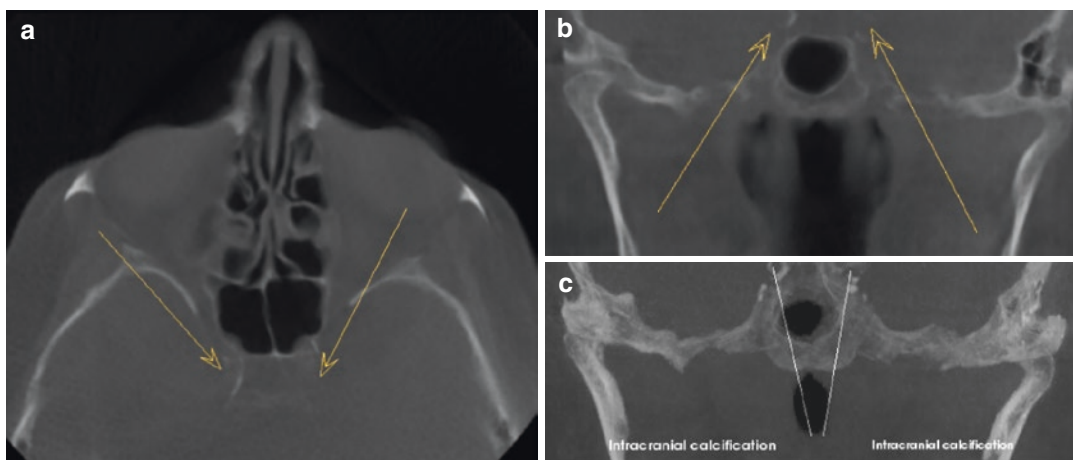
Midsagittal (a), axial (b), and coronal (c) 5 mm thick MIP CBCT images of a 67-year-old female patient with a history of controlled blood pressure and cardiovascular disease with bilateral circular calcifications of the intradural section (V4) of the vertebral
